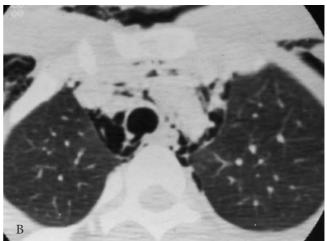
Acute tracheal tear. A, Posteroanterior chest radiograph demonstrates marked diffuse pneumomediastinum extending into the neck. B, Computed tomography scan through the upper chest reveals extensive pneumomediastinum and subcutaneous emphysema. There is a tear of the membranous wall of the trachea.
